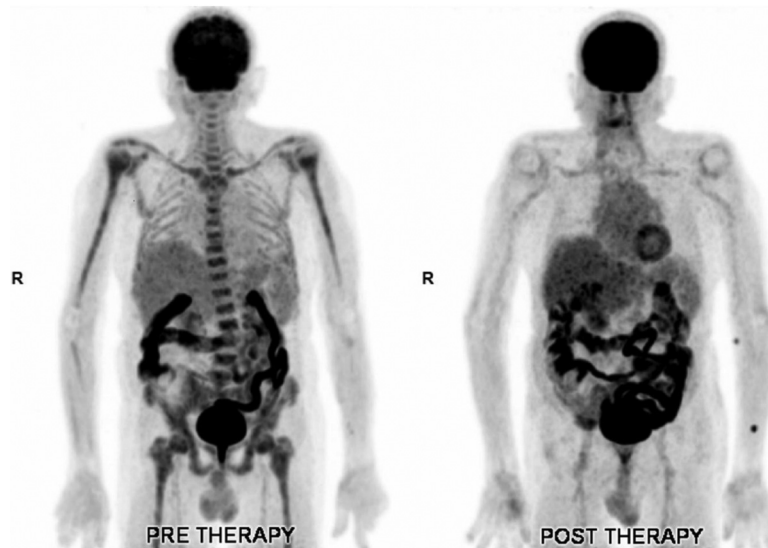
Maximum intensity projection (MIP) images of F-18 FDG PET: pretherapy PET image (*left*) shows increased diffuse abnormal F-18 FDG uptake with heterogeneity in bone marrow of axial and proximal appendicular skeleton; more heterogeneity noted along the proximal appendicular skeleton. Posttherapy PET image (*right*) shows complete resolution of previously seen F-18 FDG uptake in bone marrow. Note: The intense F-18 FDG uptake seen in bowel in pre- and posttherapy MIP images is physiological F-18 FDG uptake, with no CT-detected abnormalities. CT, computed tomography.
